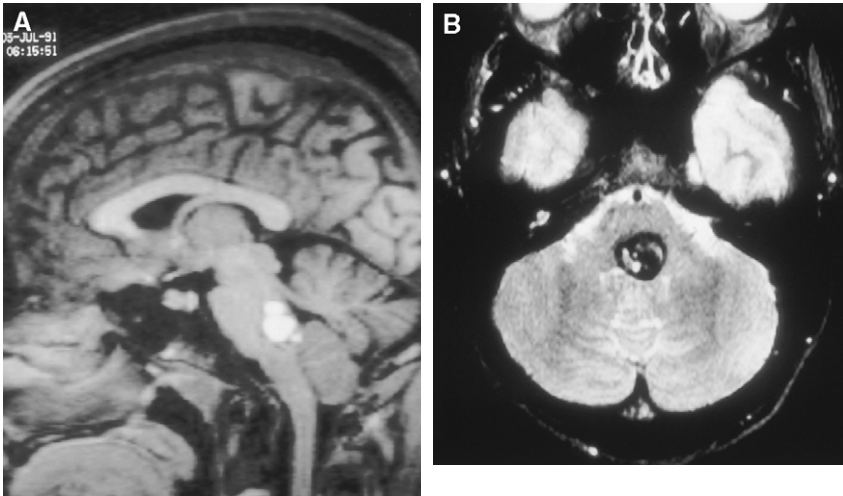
Cavernous malformation in the pontine tegmentum. (A) T1-weighted image. (B) T2-weighted image.
